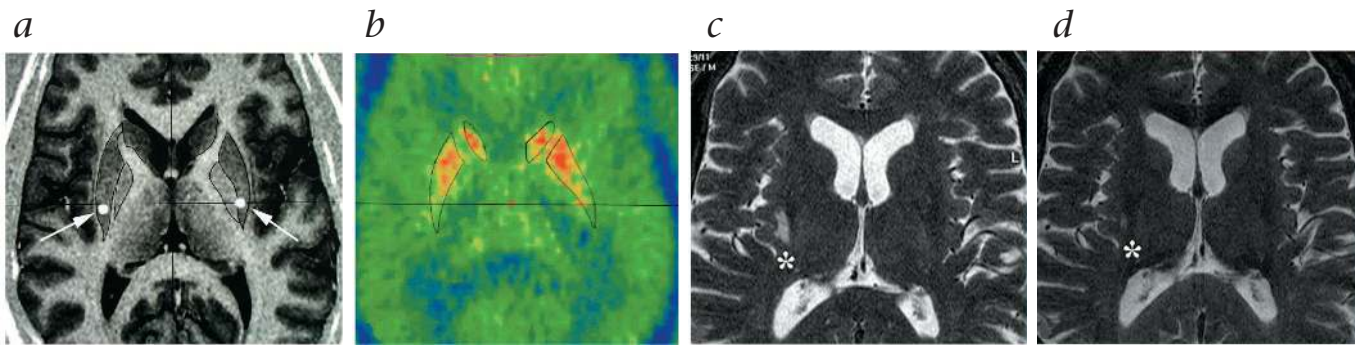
Surgical targeting and changes in MRI after chronic GDNF delivery. a, MRI scan showing targeted regions in the dorsal putamen of patient P2 (arrows and white circles). b, The marked areas showed a low [^{18}F]dopa signal in an adjacent PET image. c, High signal in the area around the catheter
